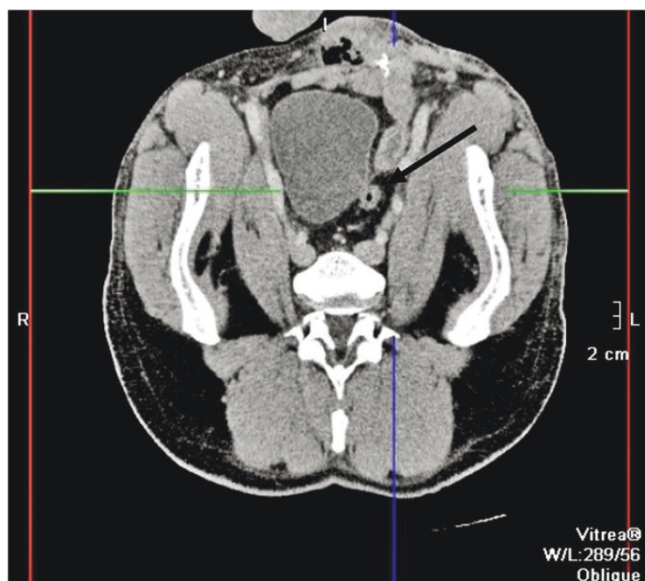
Transverse section magnetic resonance image demonstrating seminal vesicle abscess (arrowed).
